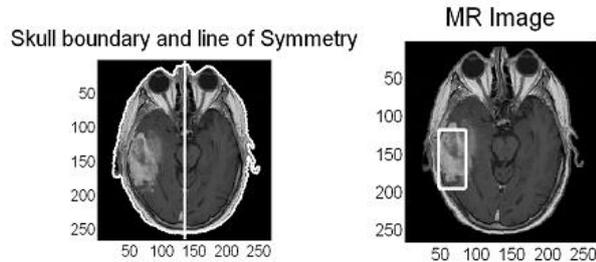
MRI Scan Slice of a patient with detected brain disease affected area in rectangular box.
